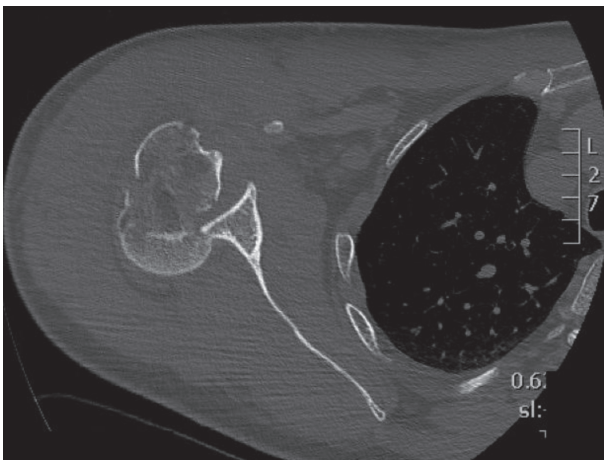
Preoperative CT scan (coronal plane)
